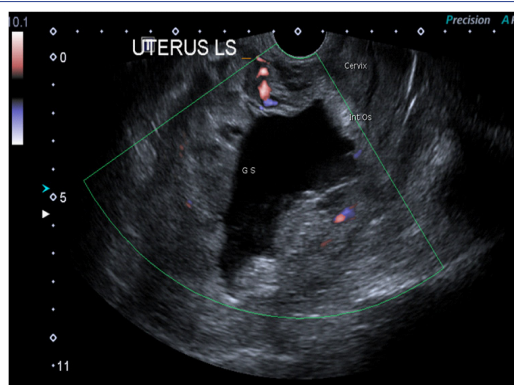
TVS in Case No 2 showing mild colour Doppler flow. The shape of the GS shows lower pole to broader above the internal os differentiating it from a GS sac descending from the uterine body. The diagnosis of CSP was missed.
